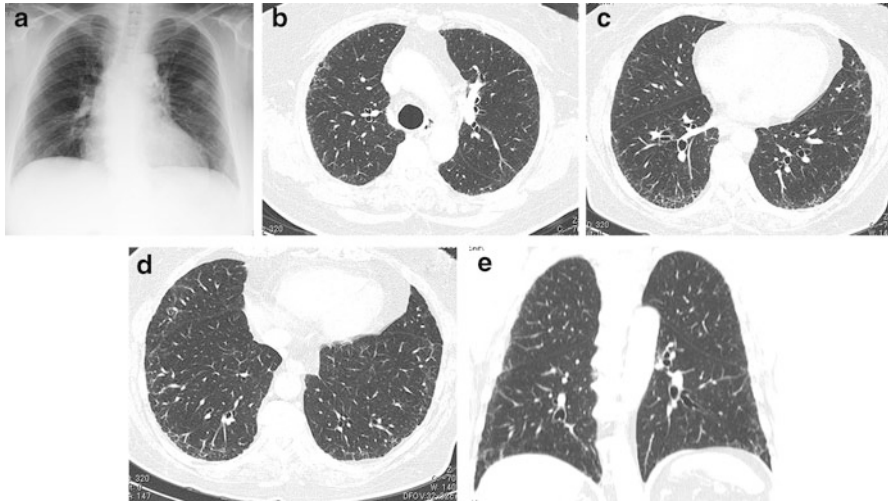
Possible usual interstitial pneumonia (UIP) pattern at high-resolution computed tomography (HRCT). (a) Chest x-ray shows ground-glass opacity predominantly in bilateral basal lungs. Nodular opacity in the left middle lung field suggests lung cancer. (b) HRCT at the upper lung shows subpleural inhomogeneous reticular opacity. (c) HRCT at the lower lung shows subpleurally located inhomogeneous reticular opacity. Reticular opacities distribute inhomogeneously. (d) HRCT at the lung base shows subpleurally distributed reticular opacity without honeycomb lung. (e) Coronal CT shows subpleural reticular opacity located predominantly in the lower lungs. No honeycombing is identified
